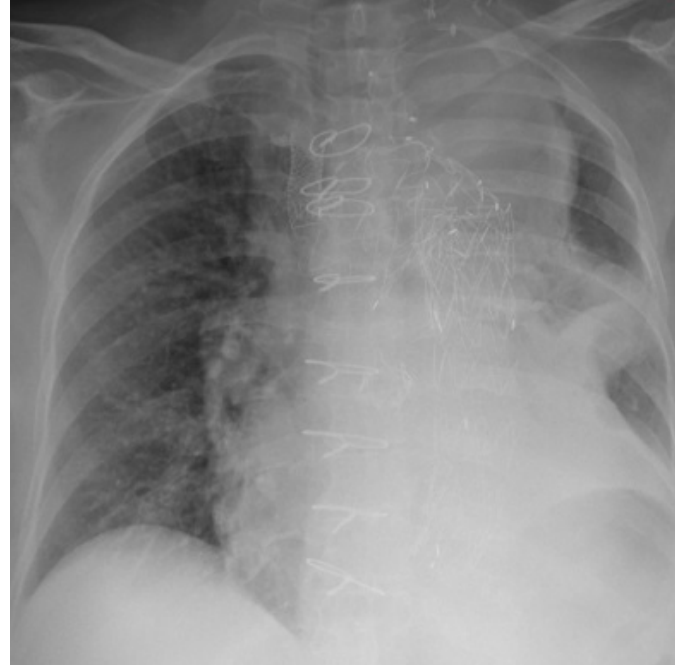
A chest X-ray shows the chimney technique used as rescue to preserve the IA patency.
